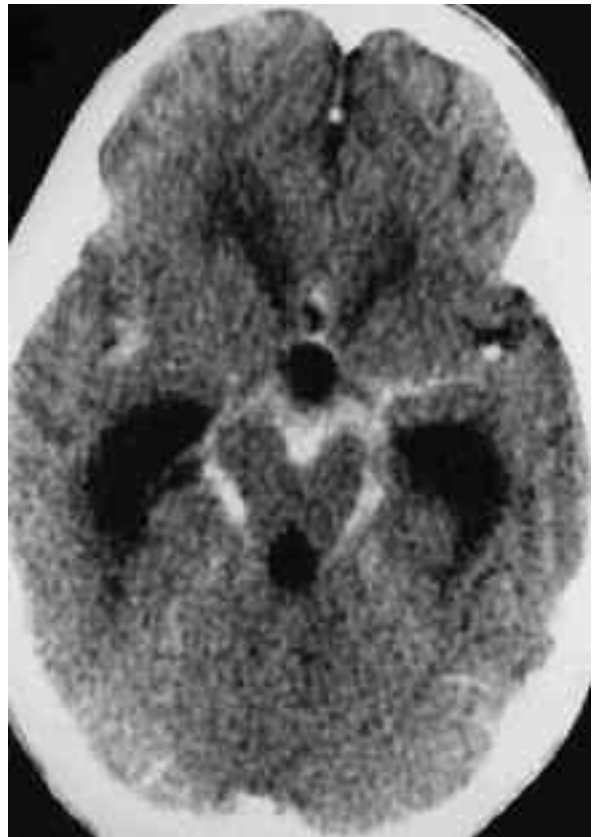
A computerized tomographic (CT) image of the Head showing thick basal exudates, ventricular dilatation is present.
